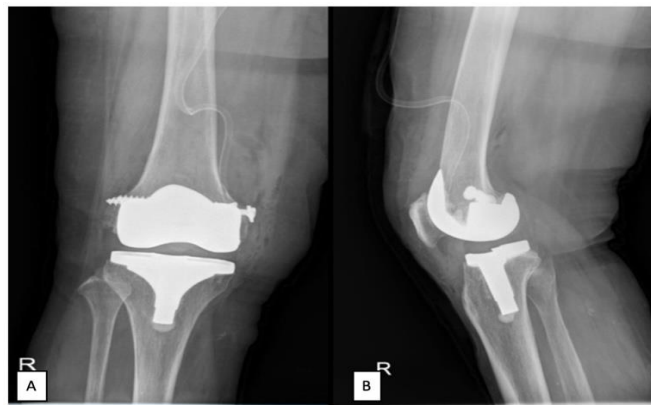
Post-operative x-ray of right knee: A) anteroposterior view; B) lateral view
